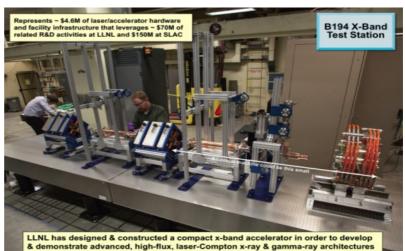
The LLNL laser-Compton test station is designed to test advanced concepts for high-flux x-ray generation and provide a capability for development of mono-energetic X-ray applications
